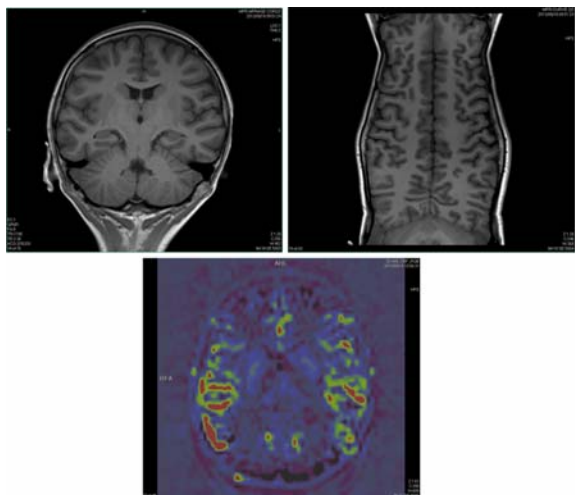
Brain MRI showed focal cortical dysplasia in medial left inferior temporal gyrus.
